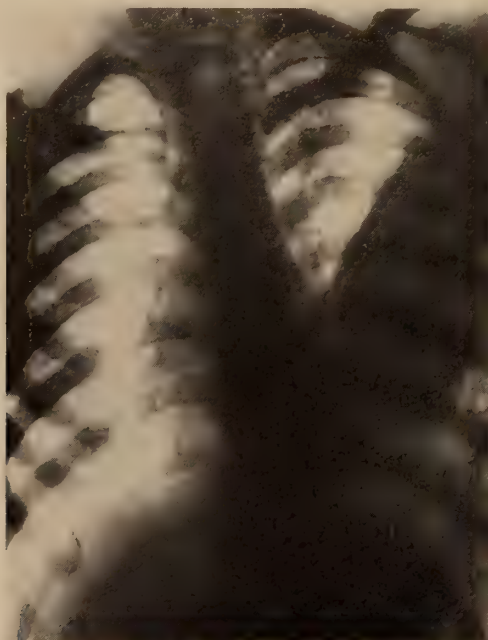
X-ray examination revealed a large shadow in the left thorax
